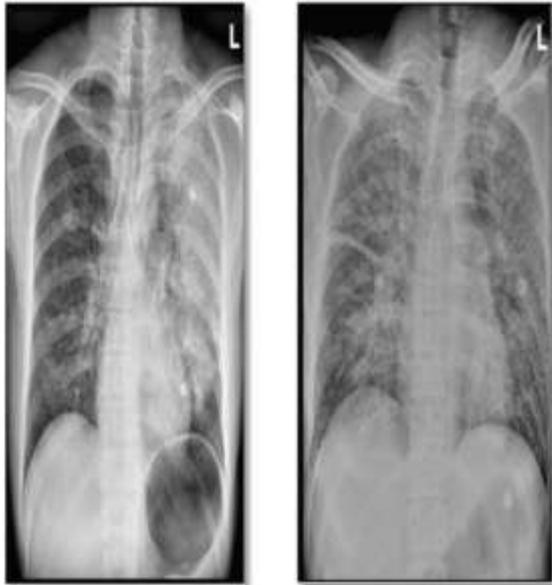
Chest radiographs of two patients with pneumonic plague.
